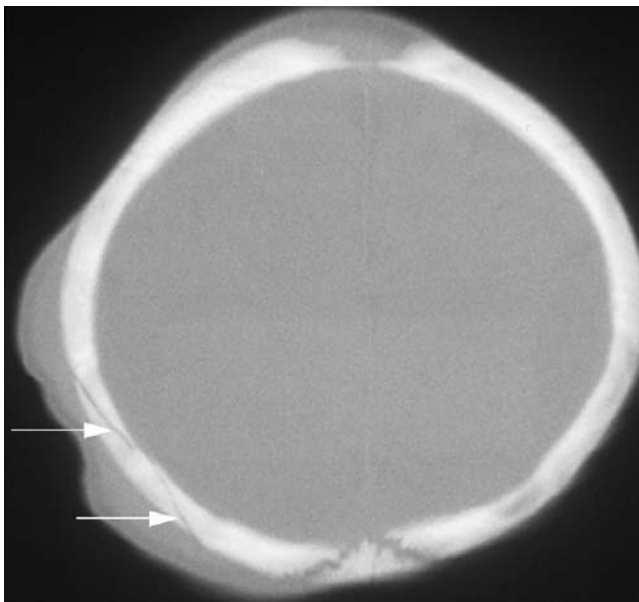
Linear skull fracture. This is a head computed tomography scan performed on a 6-month-old girl who fell down 20 steps. The *arrows* indicate a comminuted linear right parietal skull fracture. Note also the extensive soft-tissue swelling of the right parietal scalp. No intracranial abnormalities were identified.
